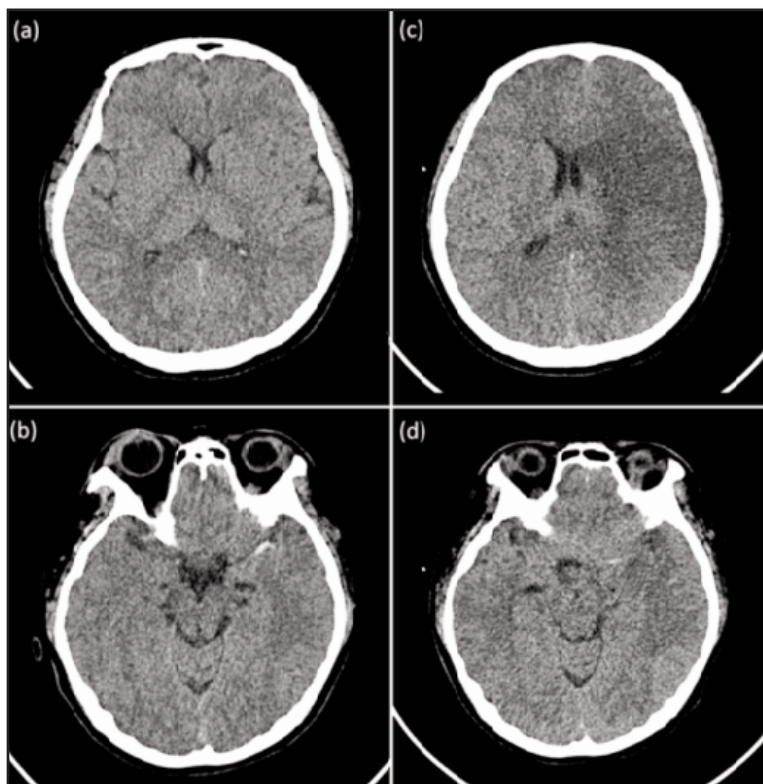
(a)(b): CT Brain on admission showed hyperdense MCA sign suggestive of early MCA infarct, no focal brain edema. (c)(d): CT brain at 48 hours showed evolving changes of acute left MCA infarct with focal cerebral edema and mass effect.
